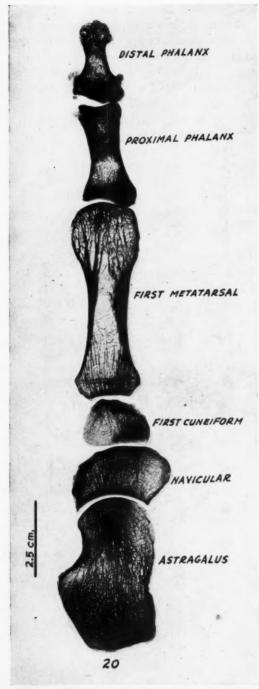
Plate X, Fig. 20. Roentgenograms of the bones of the left foot in the axis of the first metatarsal bone at right angles to the midsagittal plane. In
